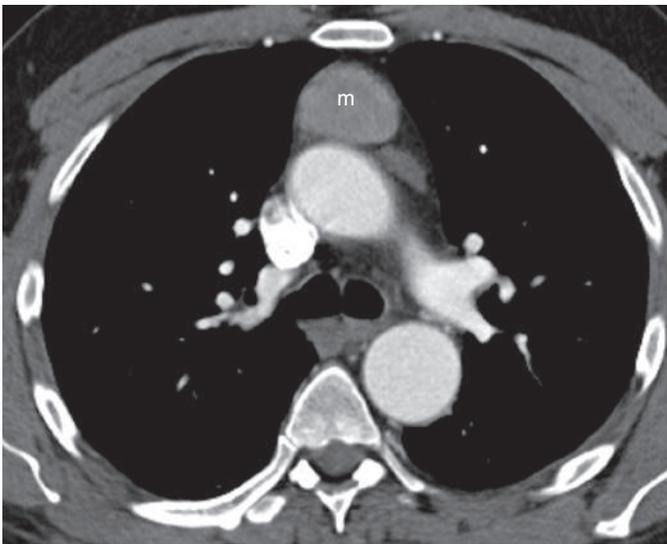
Anterior mediastinal mass. Computed tomography slice at the level of the aortic arch shows a homogeneous encapsulated anterior mediastinal mass (*m*). The diagnosis was thymoma.
